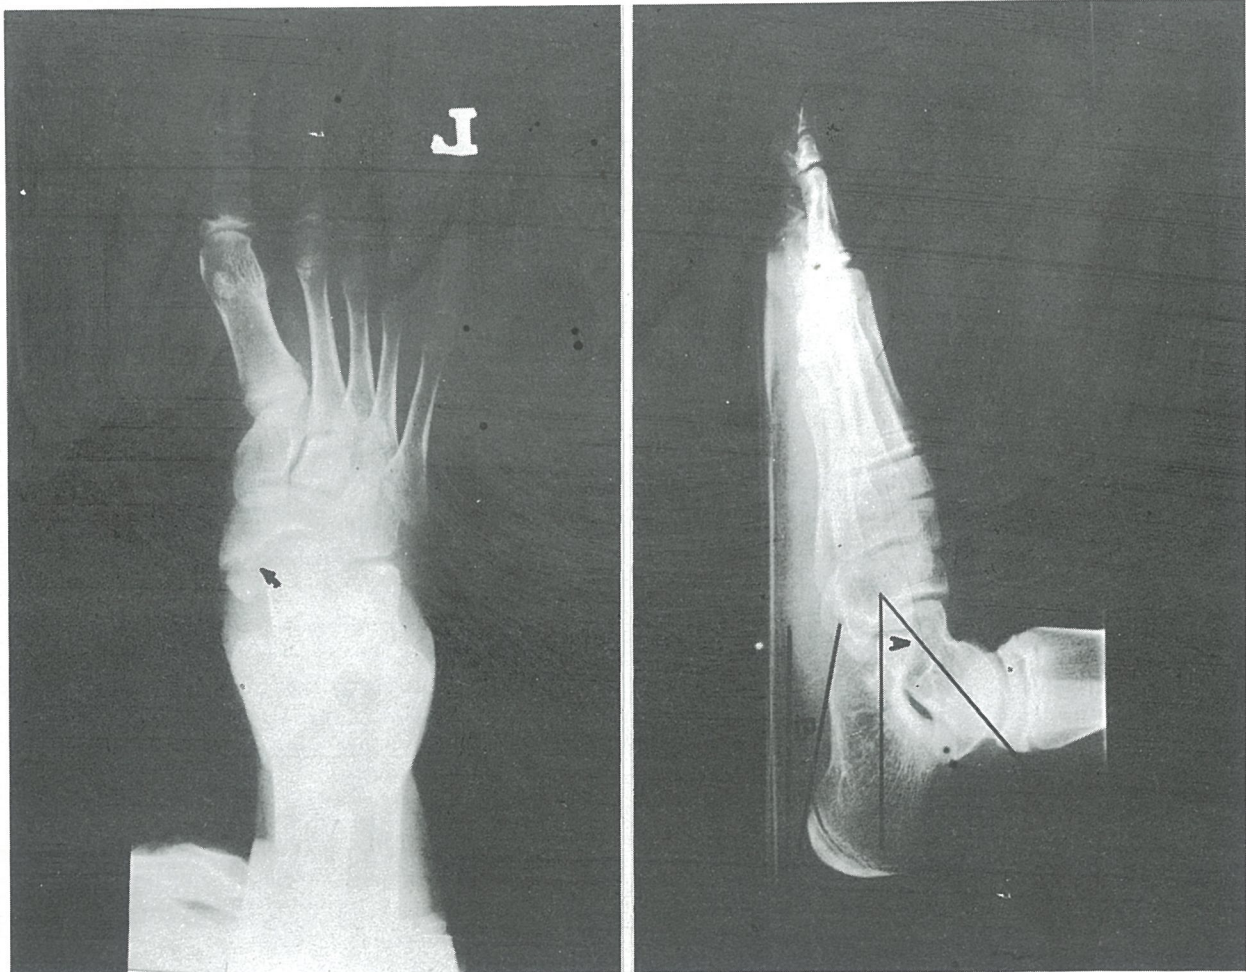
A, Anteroposterior radiograph demonstrating the type II accessory navicular with irregularity of the articulating surface. B, Lateral radiograph demonstrating the calcaneal dorsiflexion (A) and talar plantar flexion angle (B).
